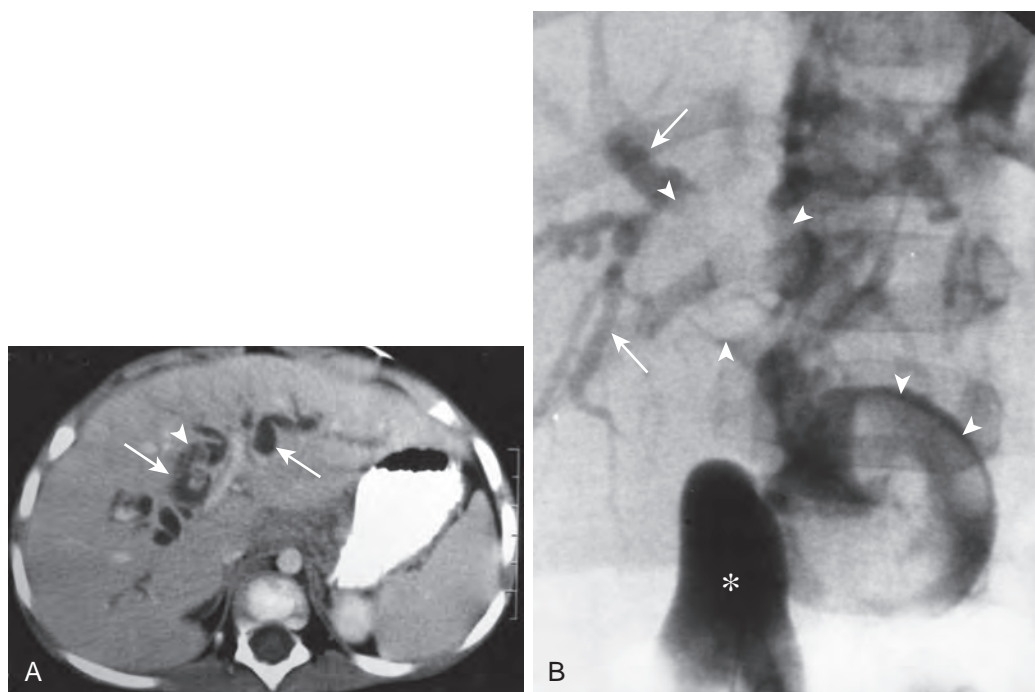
Biliary rhabdomyosarcoma. A. Contrast-enhanced CT of a 2-year-old child with fever, malaise, and jaundice. The arrows indicate the dilated intrahepatic bile ducts. In one area, there is a higher attenuation substance that may represent intraluminal sludge or an intraductal mass (arrowhead). B. Intraoperative cholangiogram obtained by injection of contrast material into the gallbladder (asterisk) demonstrates multiple filling defects (arrowheads) within the dilated bile ducts, including the common bile duct. The bile ducts proximal to the intraductal masses are also dilated (arrows). Surgical biopsy confirmed the diagnosis of embryonal rhabdomyosarcoma. (From Donnelly LF, Bisset GS III, Frush DP: Case 2: Embryonal rhabdomyosarcoma of the biliary tree. *Radiology* 208:621–623, 1998.)
